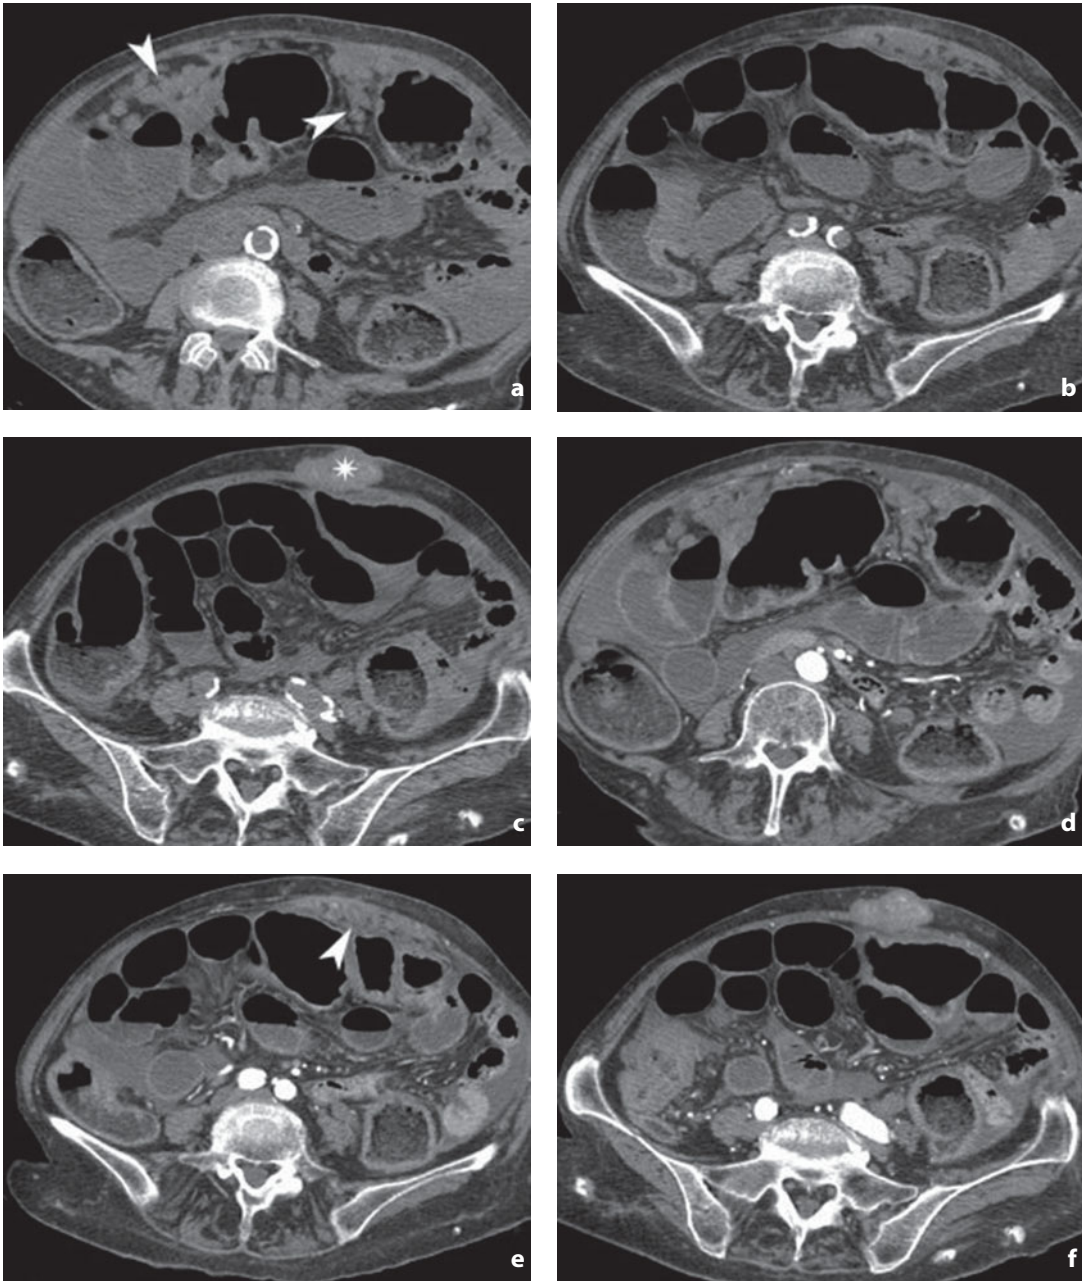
Computed tomography. Peritoneal carcinosis. a-c Nonenhanced CT shows multiple solid nodules (*arrowheads*) in the greater omentum and a Sister Mary Joseph nodule at the umbilicus (*asterisk*). d-f After contrast medium administration the nodules show marked enhancement and associated ascites is apparent
